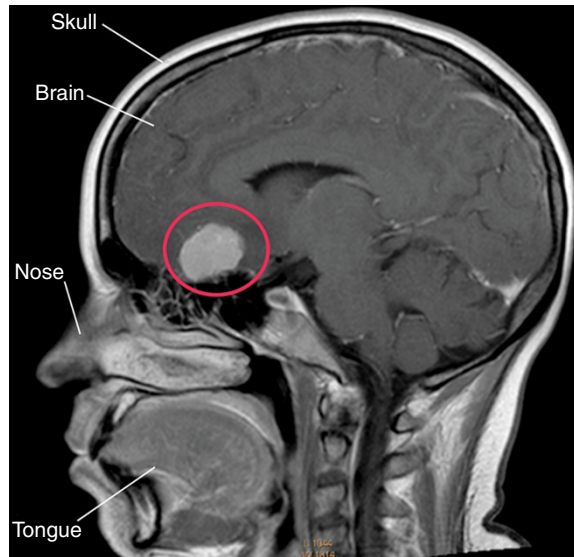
MRI of the brain of a patient with a meningioma (tumor of meninges). Note how the tumor (circled in red) is located immediately above the cribriform plate and is therefore in a perfect location to compress the olfactory bulb and thereby interfere with olfaction. Reproduced with permission and courtesy of Health@SarahRamsden.com.
